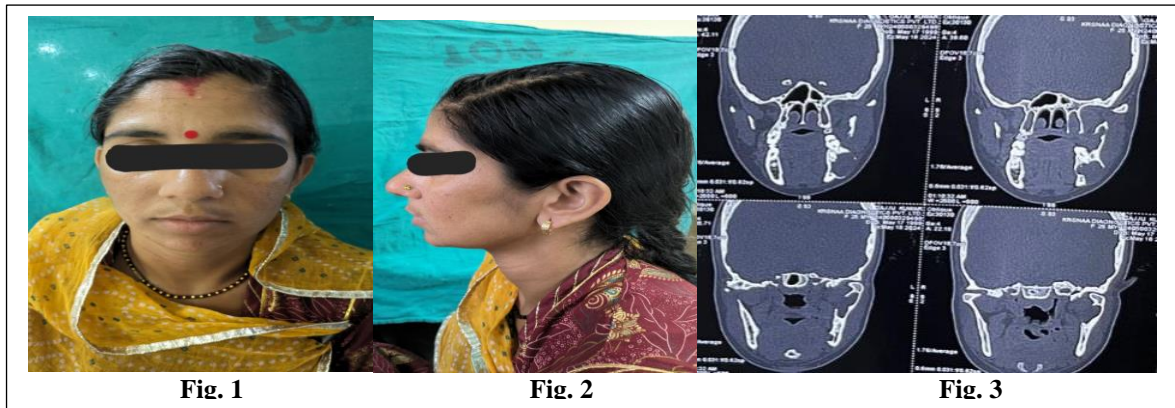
Pre operative front profile, Fig. 2 side profile, Fig. 3 coronal section of CT
